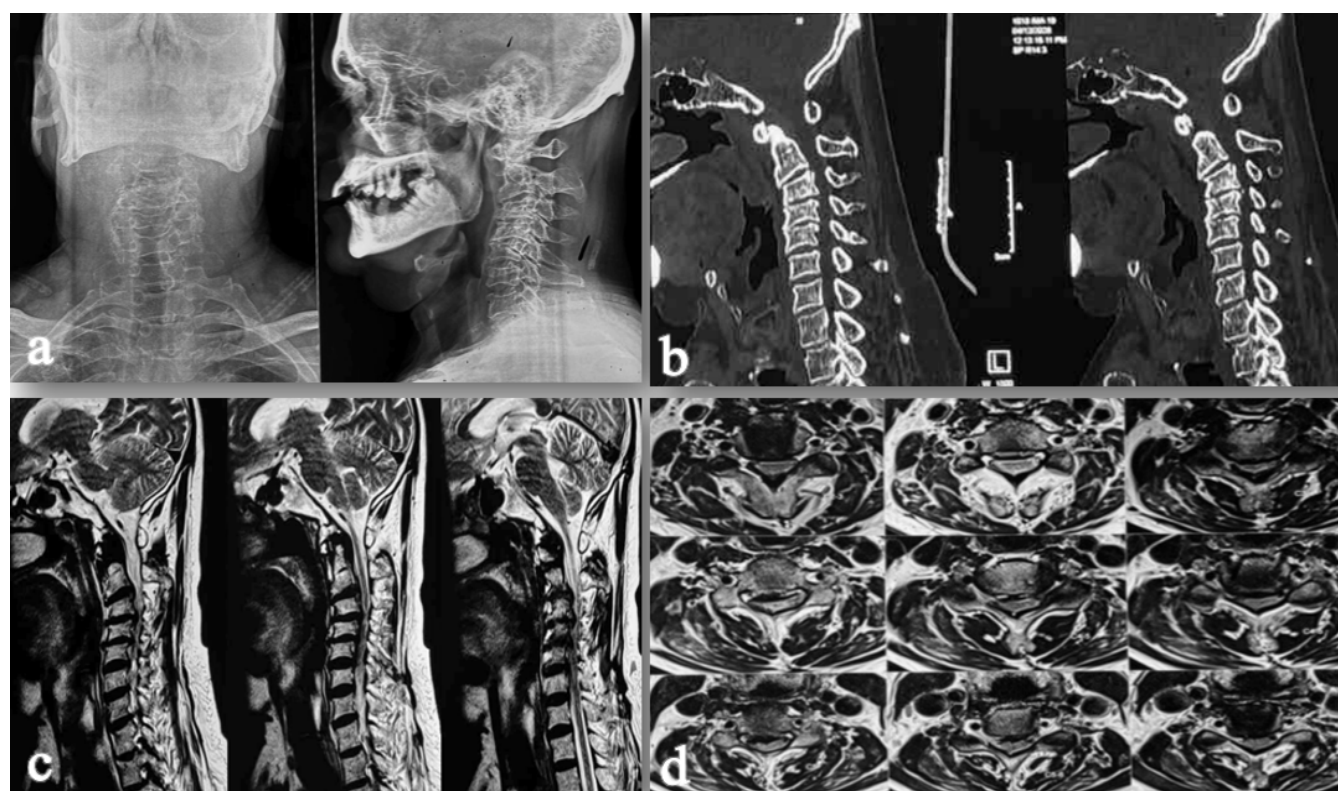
Pre-operative radiographic, computed tomography (CT), and magnetic resonance imaging (MRI) evaluation of the cervical spine. (a) Anteroposterior and lateral cervical spine radiographs demonstrating cervical alignment and degenerative spondylotic changes. (b) Sagittal CT images of the cervical spine showing multilevel degenerative changes with ossification/calcification contributing to spinal canal narrowing. (c) Sagittal T2-weighted MRI images demonstrating multilevel cervical spinal canal stenosis with cord compression and associated intramedullary T2 hyperintensity suggestive of compressive myelopathy. (d) Axial T2-weighted MRI images showing varying degrees of cervical spinal canal stenosis and spinal cord compression at multiple levels.
